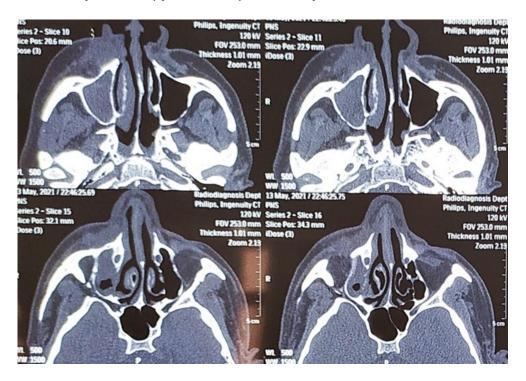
Computed tomography (axial section) of rhinoorbital region showing soft tissue swelling in the infraorbital region, maxillary sinus and nasal cavity of the right side
